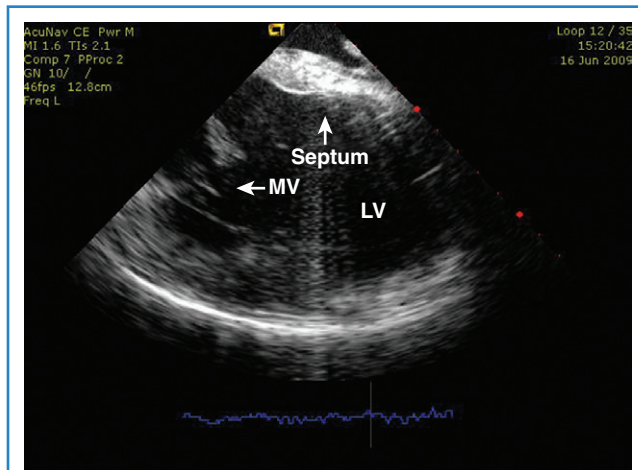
Intracardiac echocardiography image of the left ventricle (LV) in longitudinal view, demonstrating myocardial scar involving the mid to distal septum. MV, Mitral valve.
